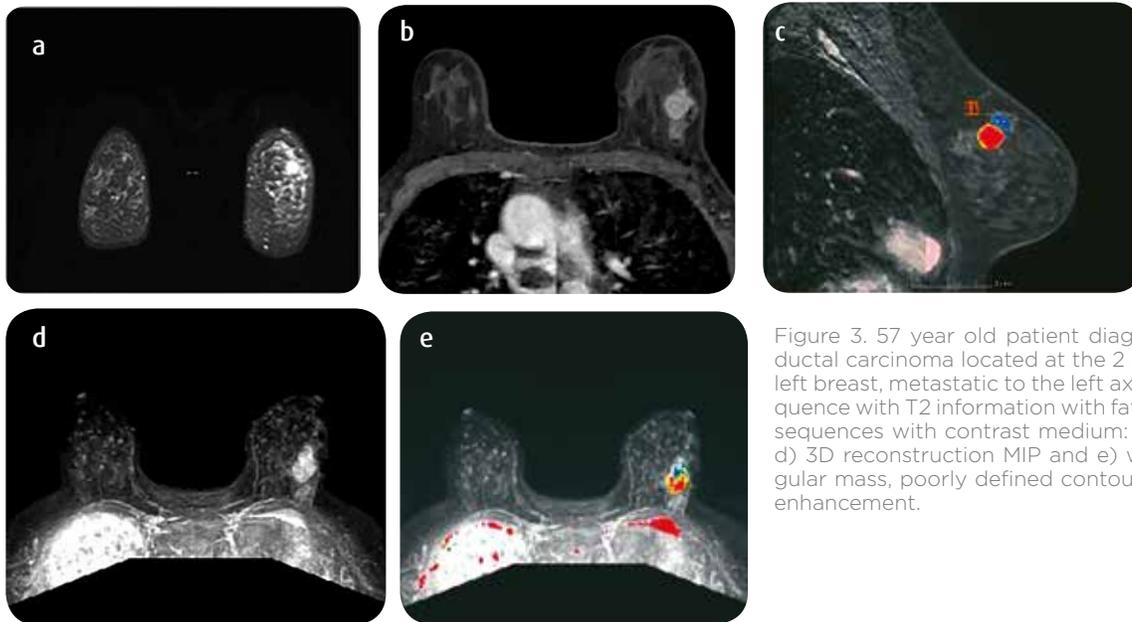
57 year old patient diagnosed with infiltrating ductal carcinoma located at the 2 o'clock meridian in the left breast, metastatic to the left axilla. a) Coronal MRI: sequence with T2 information with fat saturation. Functional sequences with contrast medium: b) coronal, c) sagittal, d) 3D reconstruction MIP and e) with CAD system. Irregular mass, poorly defined contours and Heterogeneous enhancement.
